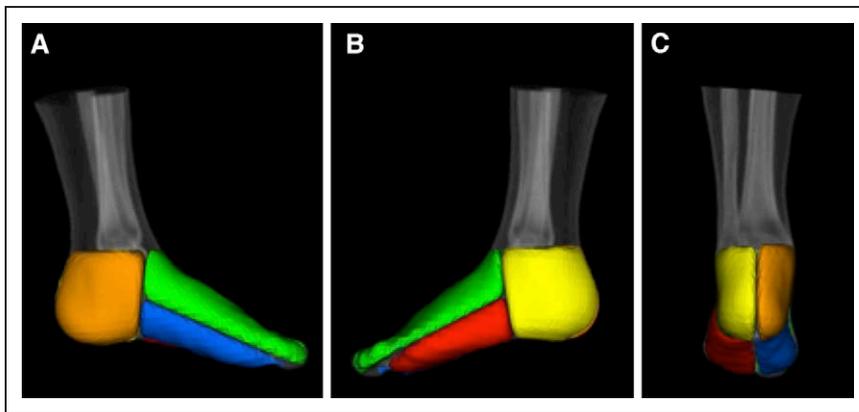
Volume rendered foot angiosomes overlaid on X-ray computed tomography attenuation images acquired in a patient with critical limb ischemia.
